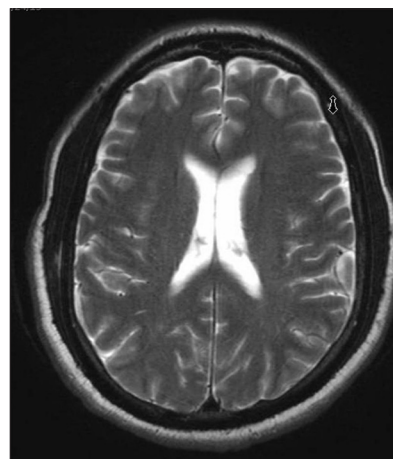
T2-weighted axial MRI of the brain showing no obvious abnormality
